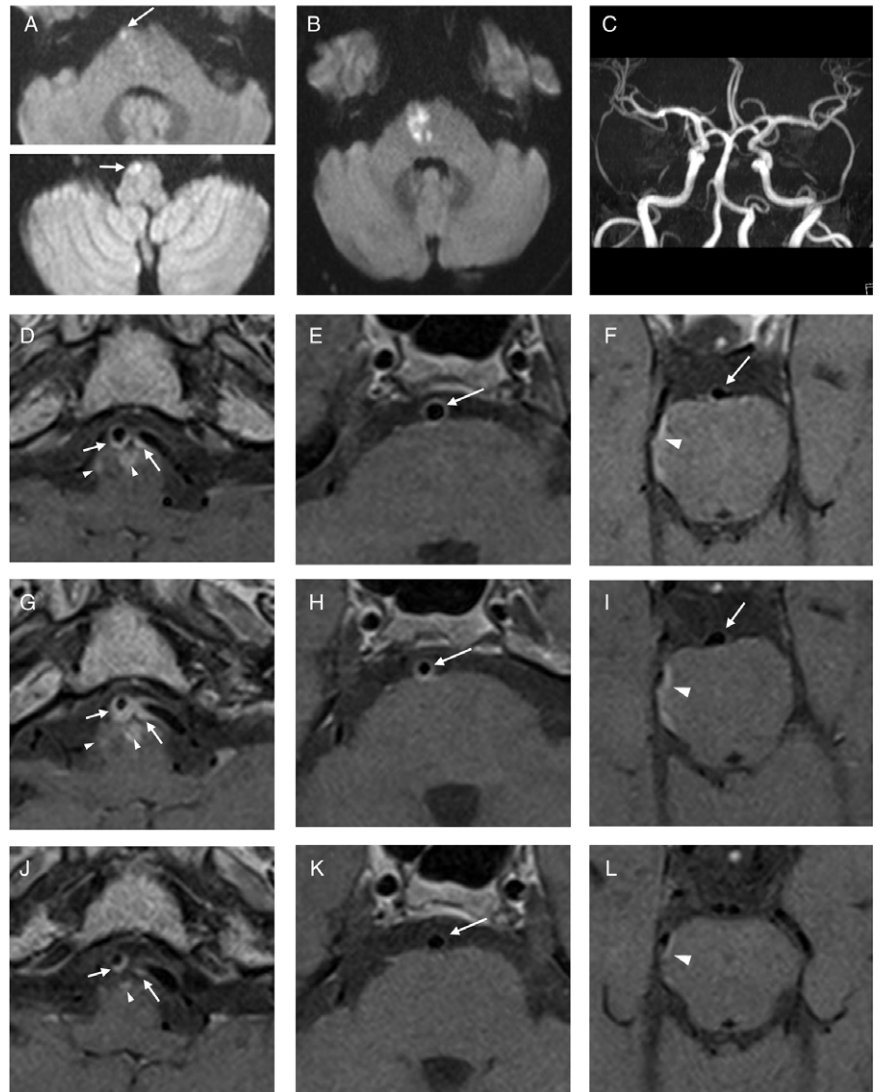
Multifocal brainstem infarct secondary to varicella zoster virus vasculopathy involving bilateral vertebral and basilar arteries. Lesions with abnormal diffusion restriction on MRI were seen in right anterior medulla oblongata (bottom) and right medial pons (top) on day 2 after Emergency visit (A), and a new lesion was seen in right paramedian pons on day 8 (B). Magnetic resonance angiography showed no definite stenosis of intracranial vessels (C). Gadolinium enhanced high-resolution vessel wall MRI showed vessel wall enhancement in bilateral distal vertebral arteries (D, arrow), middle basilar artery (E, arrow) and faintly in distal basilar artery (F, arrow), as well as focal leptomeningeal enhancement in medulla and pons (D, F, arrowhead) on day 8. The wall enhancement became thickened in vertebral arteries (G), remained stationary in middle basilar artery (H), and resolved in distal basilar artery (I) on day 49. On day 256, the vertebral artery wall enhancement partially remitted (J), the middle basilar artery enhancement completely resolved (K), and the leptomeningeal enhancement became faint (J, L).
